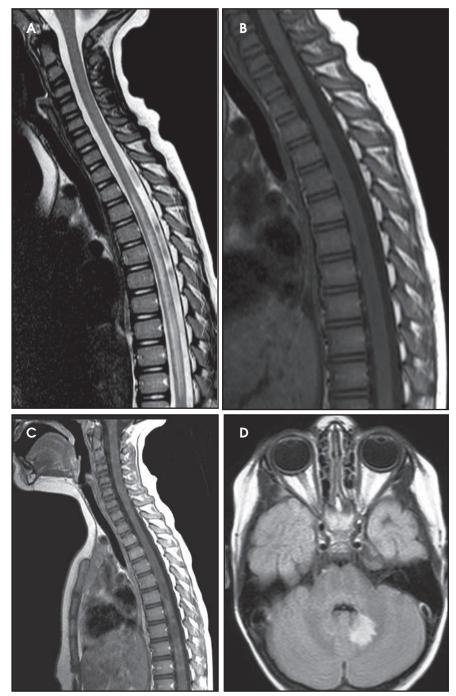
A 12-year-old female with ADEM. (A) Sagittal T2W image shows central cord hyperintensity. (B) Sagittal precontrast imaging for comparison. (C) Postcontrast imaging shows ill-defined patchy enhancement of the spinal cord. (D) Axial FLAIR imaging shows left cerebellar hyperintensity.
